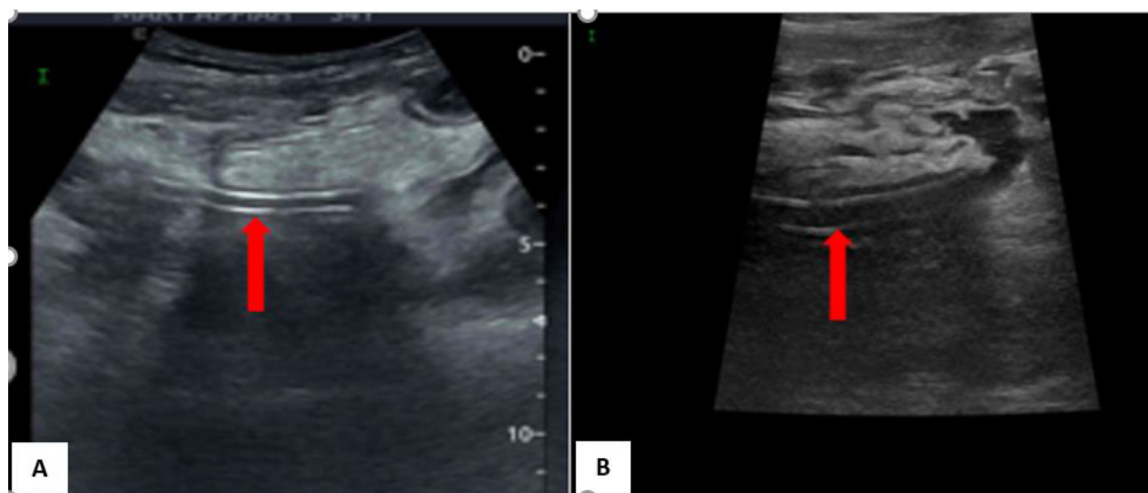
Pelvic Ultrasound images acquired using (A) curvilinear and (B) Linear probes showing the tubular structure (red arrows) with the associated heterogeneous subcutaneous collection.
